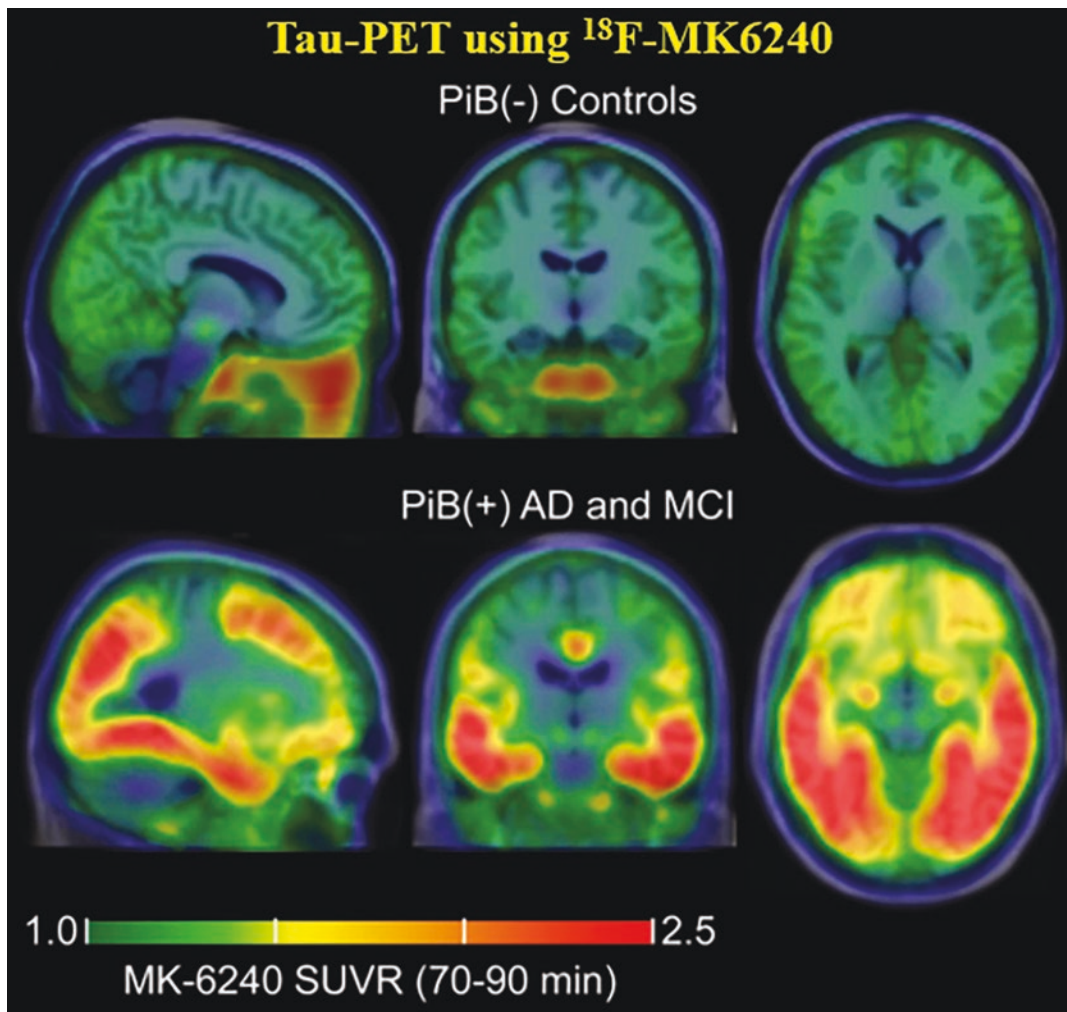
Mean parametric ^{18}F -MK-6240 SUVR(70–90 min) images taken across controls (top, $n = 29$) and PiB(+) AD and MCI individuals (bottom, $n = 6$) in MNI
